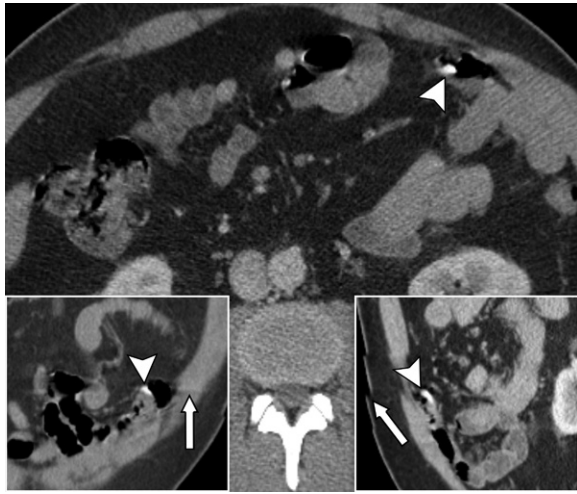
Cone beam artifact mimicking contrast extravasation. Axial (main image), coronal (left inset), and sagittal (right inset) portal venous phase CT images show a hyperattenuating focus at the interface between air and normal bowel fluid (arrowhead in all images), which is consistent with cone beam artifact. Additional findings to distinguish this artifact are the significantly higher attenuation of the artifact (271 HU) compared with that of the aorta (107 HU) and that of the inferior vena cava (90 HU), the adjacent streak artifact (arrow in left inset), and the adjacent abdominal wall stair-step artifact from patient motion (arrow in right inset).
